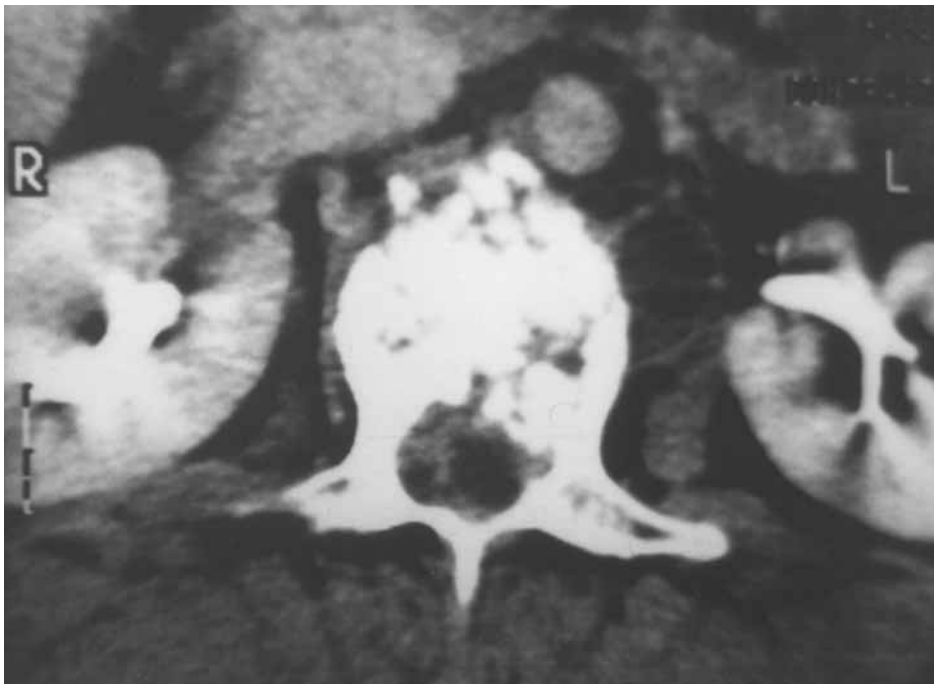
Axial CT scan showing rupture of the anterior cortex of L2, with moth-eaten aspect of the body of L2. Soft tissue masses can be seen within the spinal canal and in the right prevertebral area.
